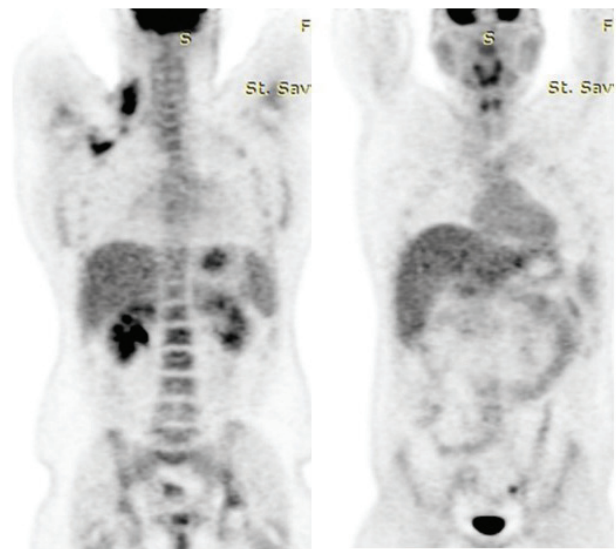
FDG PET- MIP images -of the PET CT case mentioned in Fig.8
